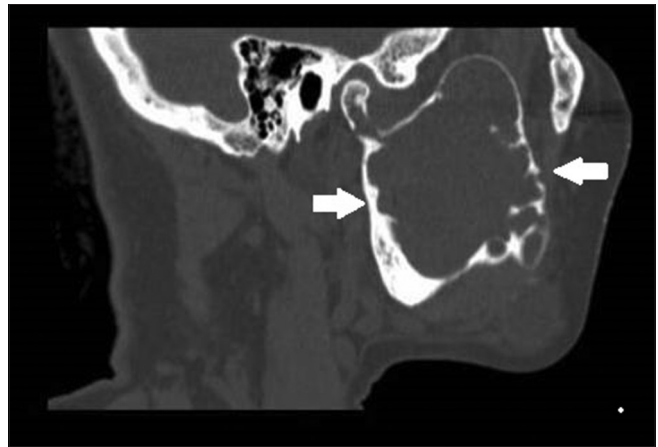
Computed tomography sagittal view showing multiple locules on the right side of the mandible with expansion and thinning of both cortical plates and perforation in the region of the anterior border of the ramus
